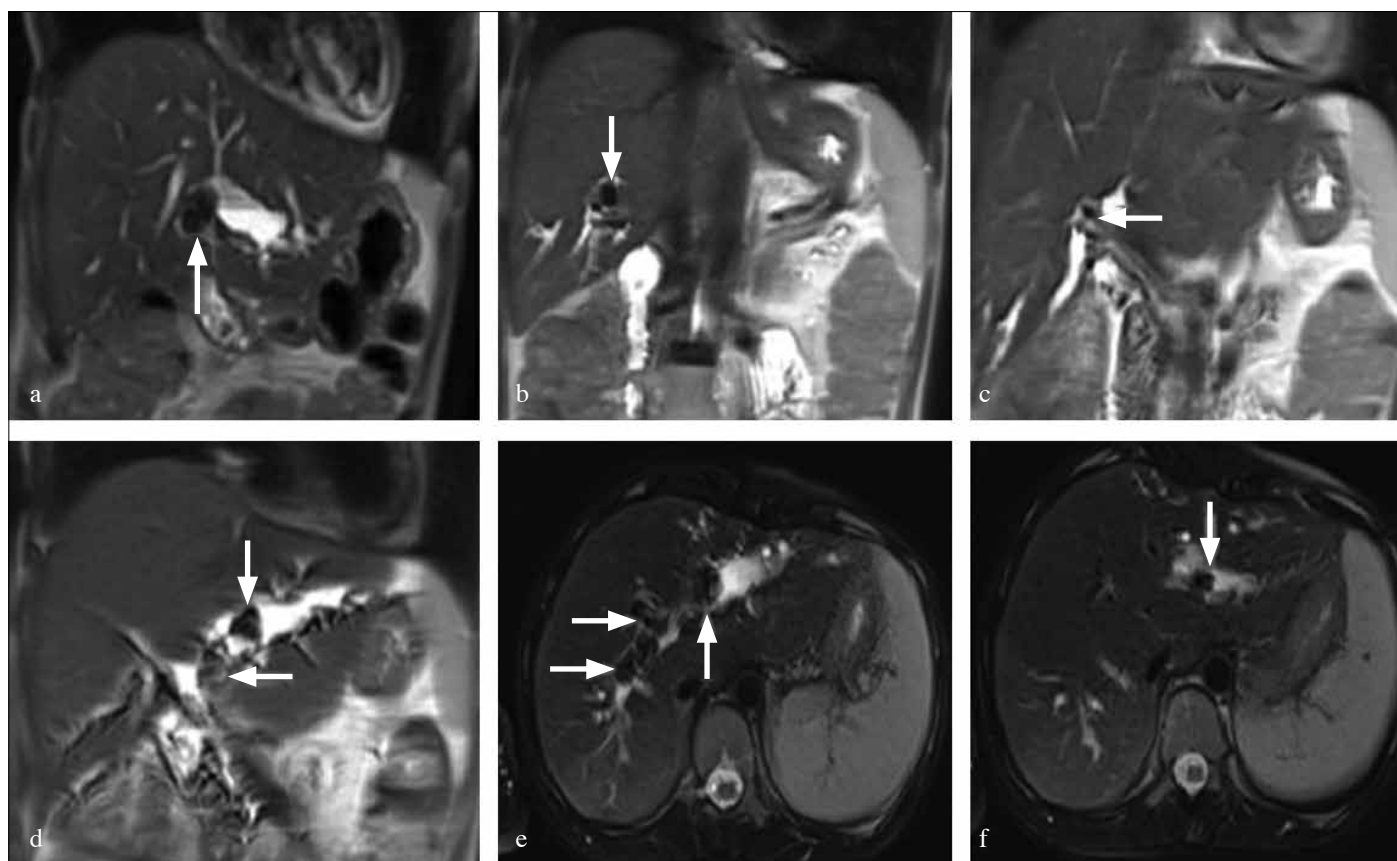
a-f. MRI images of multiple hepatolithiasis; (a-d): Image of MRI: coronal plane, (e,f): Image of MRI: axial plane
